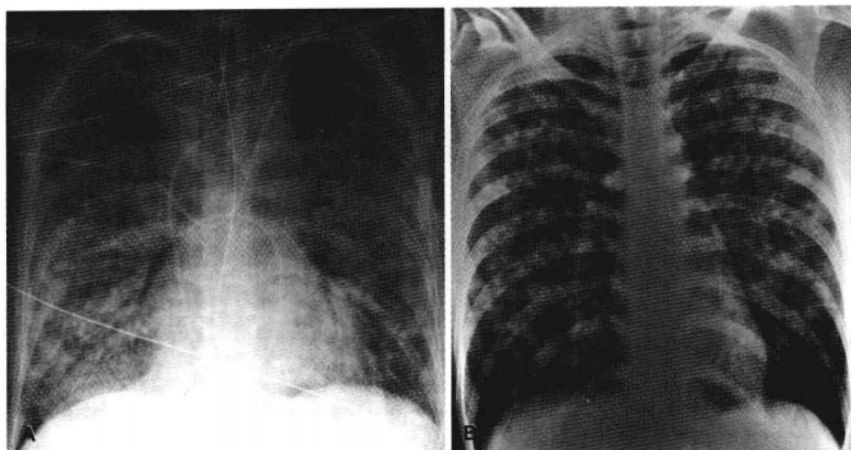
A, Patient with diffuse alveolar damage. Chest radiograph shows diffuse homogeneous opacification of both lungs with clearly visible air bronchograms. B, Patient with acute varicella pneumonia. Chest radiograph demonstrates multiple "acinar" nodules with tendency for confluence, yielding multifocal patchy parenchymal opacification.
